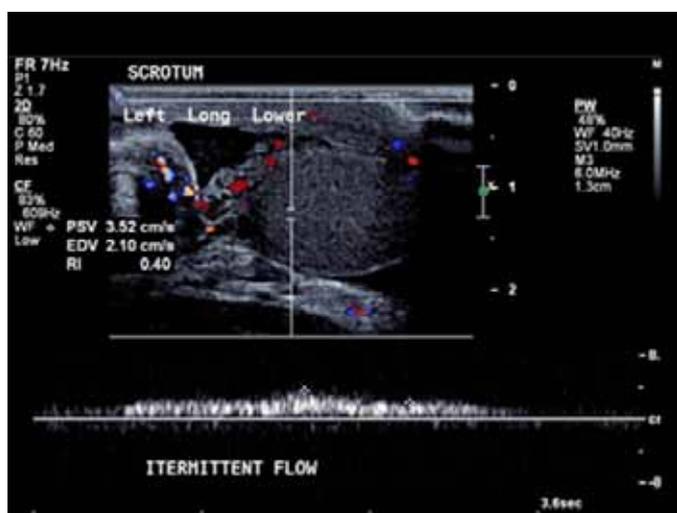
Left lower testis measured 1.7x3.3 cm and decreased Doppler flow to the testis.
